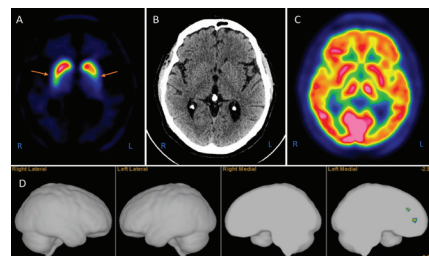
Example of [¹¹C]PE2I PET/CT images in a patient with Parkinson's disease with predominantly right-sided clinical symptoms. (A) [¹¹C]PE2I images of DAT availability showing asymmetrically reduced uptake in striatum (orange arrows), more pronounced on the left side. (B) CT image at the level of striatum showing no abnormalities. (C) [¹¹C]PE2I image of rCBF showing normal perfusion in the cortex and striatum. (D) 3D surface projection map showing perfusion z-scores compared to a healthy control database, indicating perfusion in the normal range in all cortical regions.
